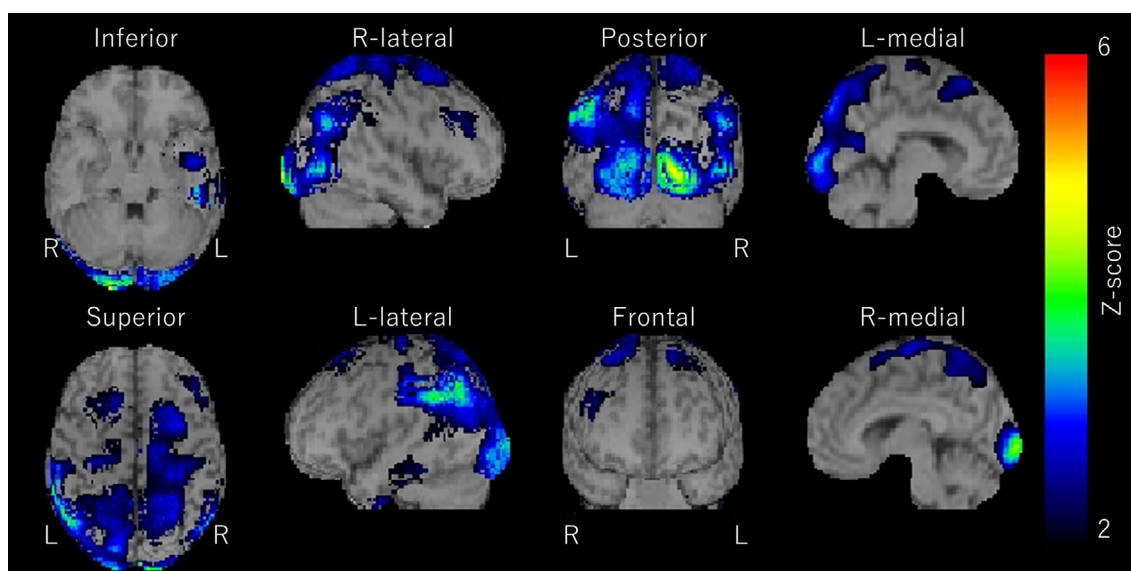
Findings on brain single-photon emission computed tomography (SPECT) with ^{99m}Tc -ethyl cysteinate dimer using the easy Z-score imaging system analysis. The color scale for the Z score is shown on the right side of the figure. Images are presented in color when the Z-score is >2 . Hypoperfusion is visible in the parietal and occipital lobes. L: left, R: right
